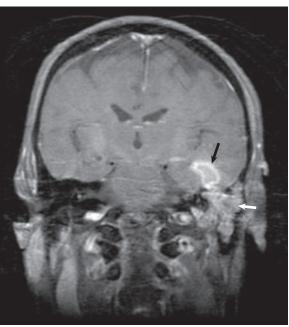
Coronal enhanced T1-weighted MRI of the patient showing enhancing tissue in left mastoid (white arrow) and temporal lobe abscess with enhancing capsule (black arrow). (From Budenz CL, El-Kashlan HK. Complications of temporal bone infections. In: Flint PW, Francis HW, Haughey BH, et al, eds. Cummings Otolaryngology Head & Neck Surgery, 7th ed., vol. 2. Philadelphia: Elsevier; 2021: Fig 141.17D)
